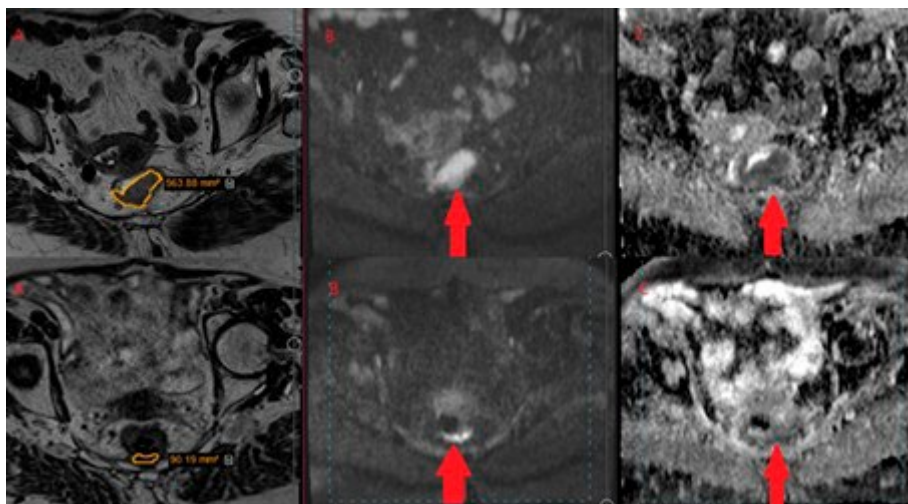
Representative MRI scans of rectal cancer before (upper panel) and after treatment (lower panel) in the same transverse section
